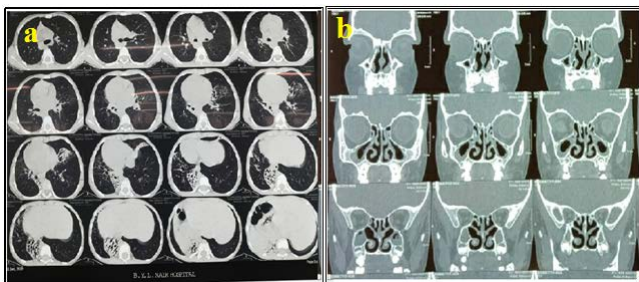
a) CT chest and b) CT of the Para Nasal Sinuses
